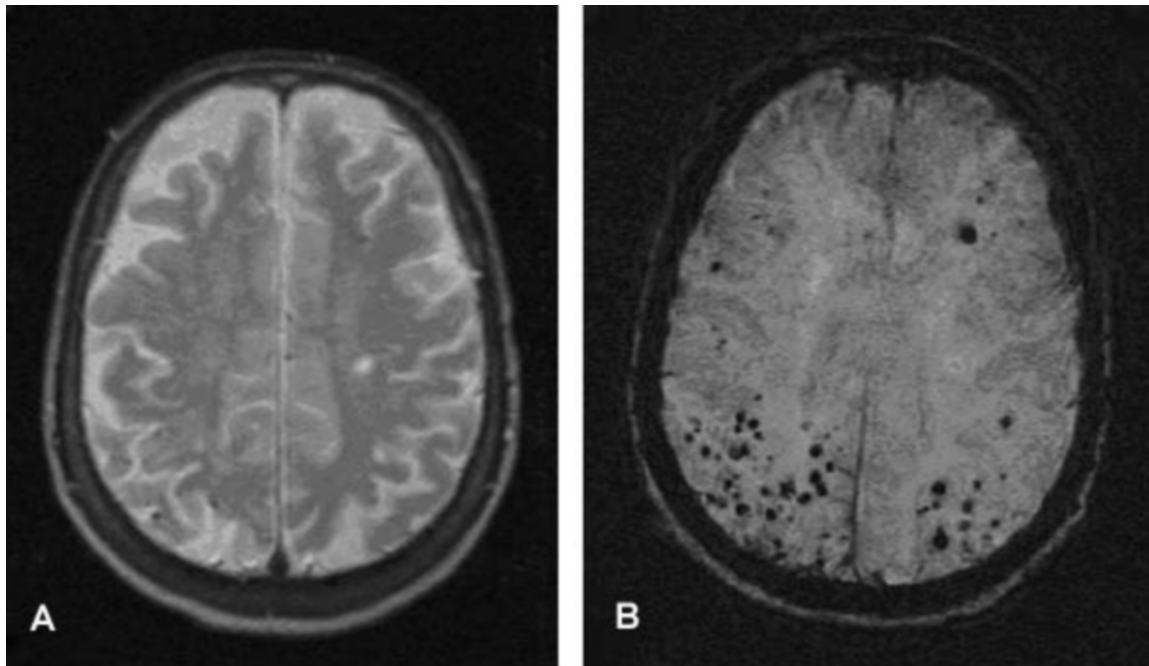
88-year-old woman with severe dementia. Axial GE-T2\* MRI and corresponding SWI MRI through the centrum semiovale. A, The GE-T2\* image shows two small foci of hemorrhage in the right parietal lobe. B, The corresponding SWI image shows numerous hemorrhages in the frontal and parietal lobes.
